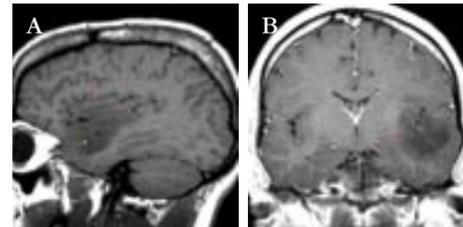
Left MCA infarct involving both trunks of MCA. A. Sagittal contrast T1-weighted image through the left insular cortex shows diffuse involvement of the insular cortex (→). Note swelling of adjacent cortex of the fronto-orbital opercular (↔), frontoparietal opercular (↔) and temporoopercular cortex (↔). B. Axial diffusion weighted image show restricted diffusion involving the entire insular cortex (→) and adjacent opercular and superficial cortex (↔).
